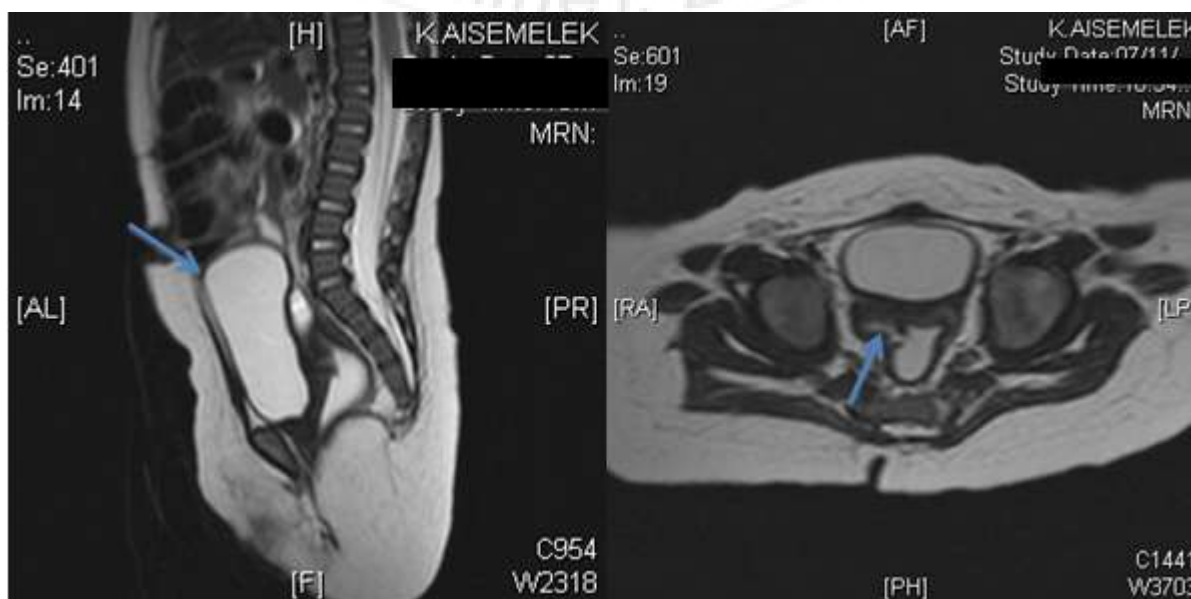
MRI showed the fistula communication with very high urinary bladder
